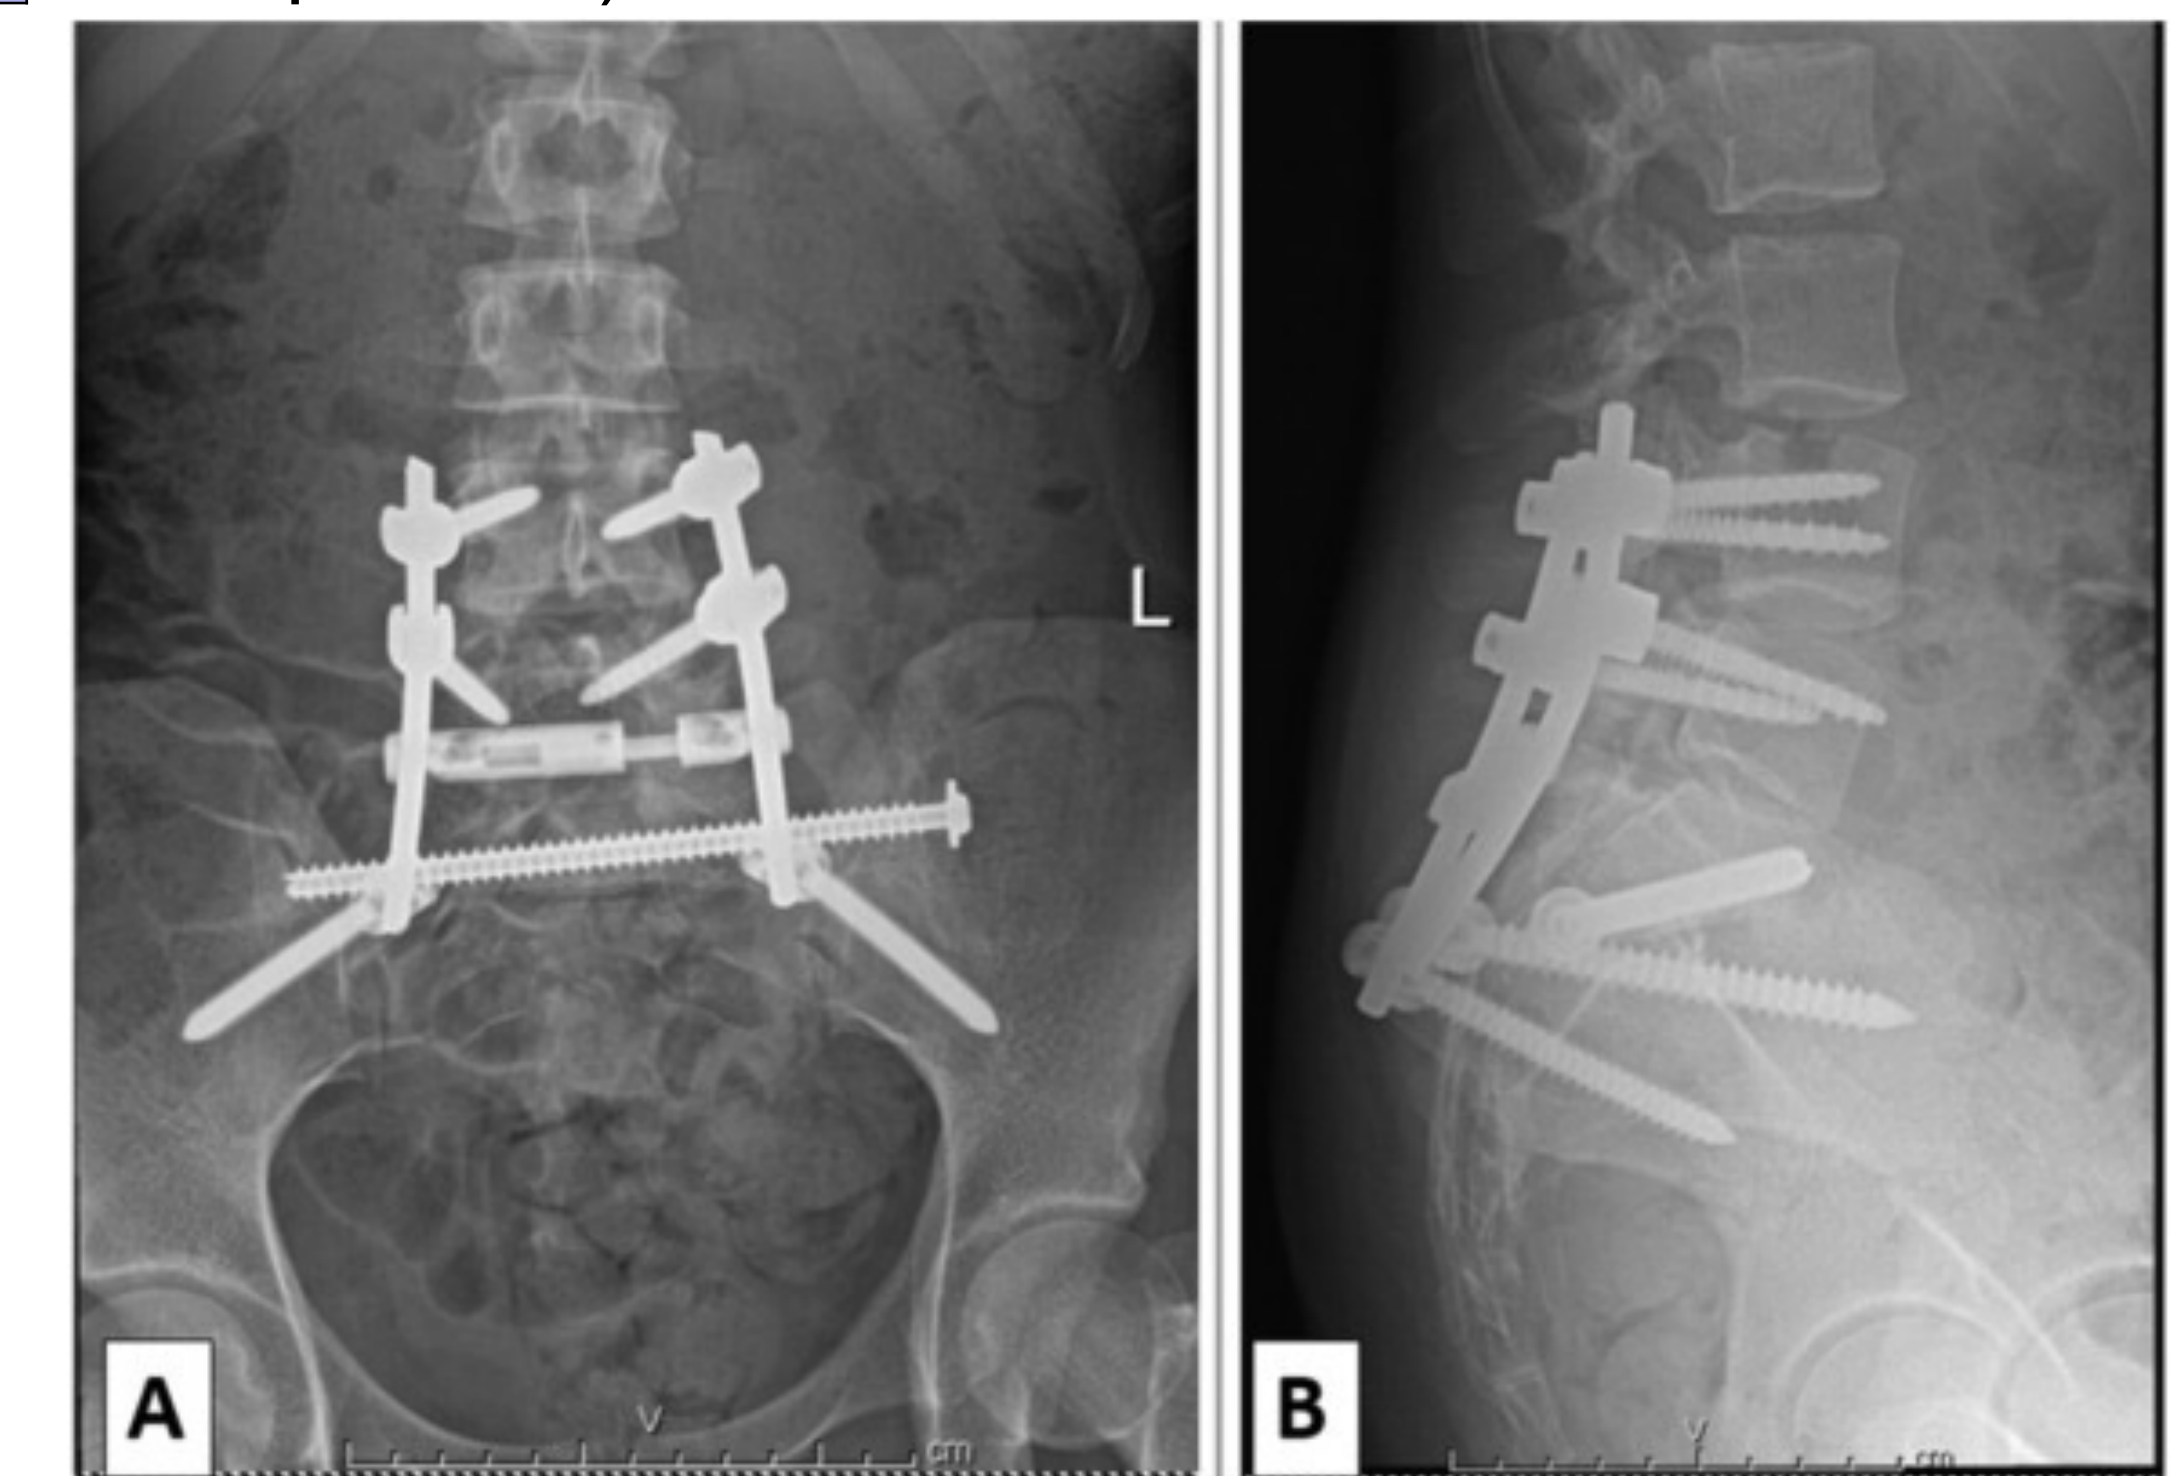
features posterior to anterior (A) and lateral (B) radiographic images of a lumbopelvic fixation osteosynthesis surgical construct. The construct includes L4 screws, L5 screws, and iliac screws, connected by rods bilaterally. An ilio-sacral screw is also included in the construct for pelvic stabilization³.
